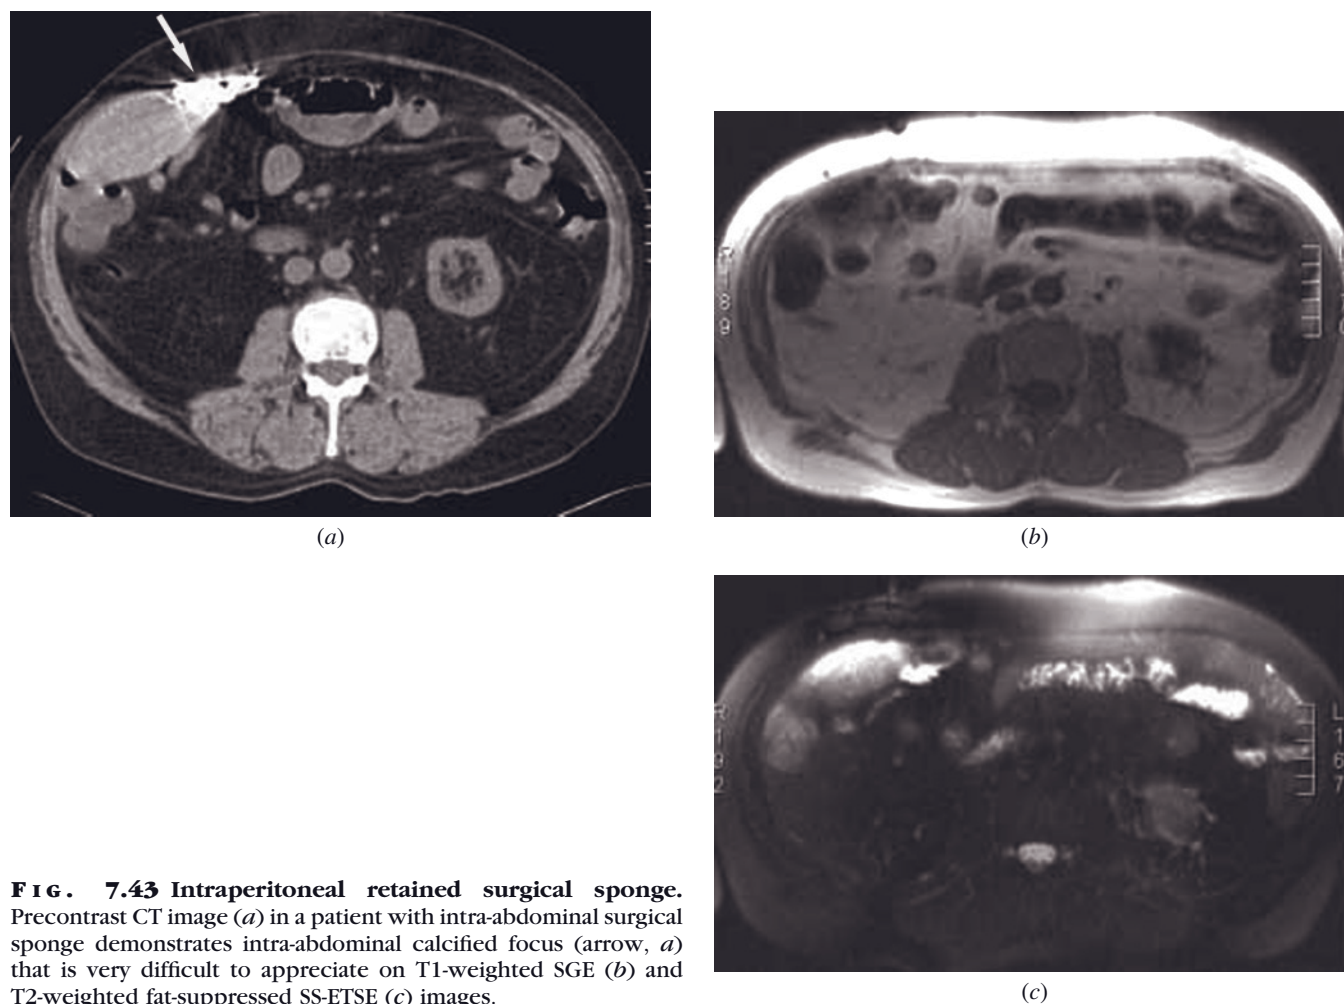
Intra-abdominal retained surgical sponge. Precontrast CT image (a) in a patient with intra-abdominal surgical sponge demonstrates intra-abdominal calcified focus (arrow, a) that is very difficult to appreciate on T1-weighted SGE (b) and T2-weighted fat-suppressed SS-ETSE (c) images.
